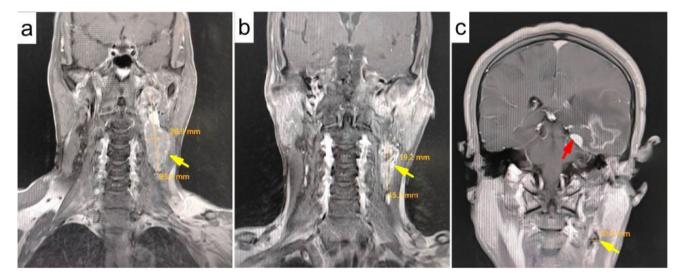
Comparative Pre-/Post-Treatment Imaging of Cervical Lesions (Coronal T1WI MRI). a Baseline cervical MRI at initial diagnosis of cervical lesions(yellow arrow). b 1-month post-radiotherapy cervical MRI follow-up. c 1-year post-radiotherapy cranial MRI surveillance
